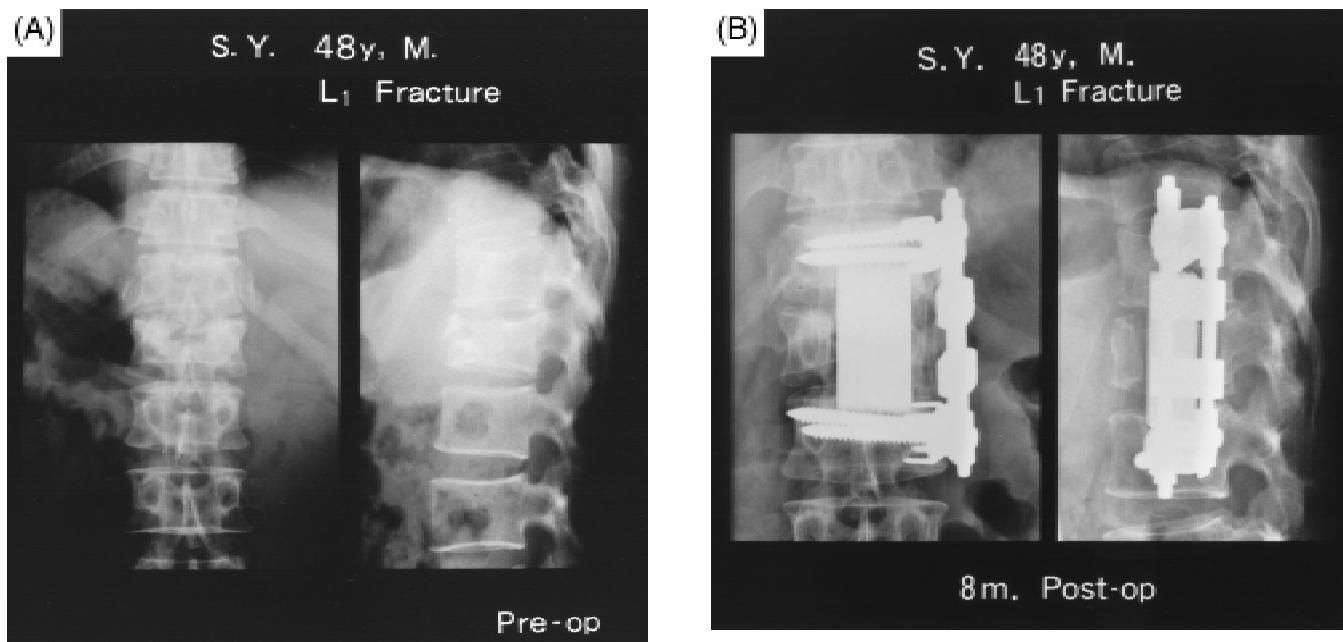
X-rays of a case of burst fracture of the L₁ vertebra: (A) preoperative anterior-posterior and lateral views and (B) postoperative anterior-posterior and lateral views using bioactive glass-ceramic A/W prosthesis. (Photo courtesy of Professor T. Yamamuro.)
